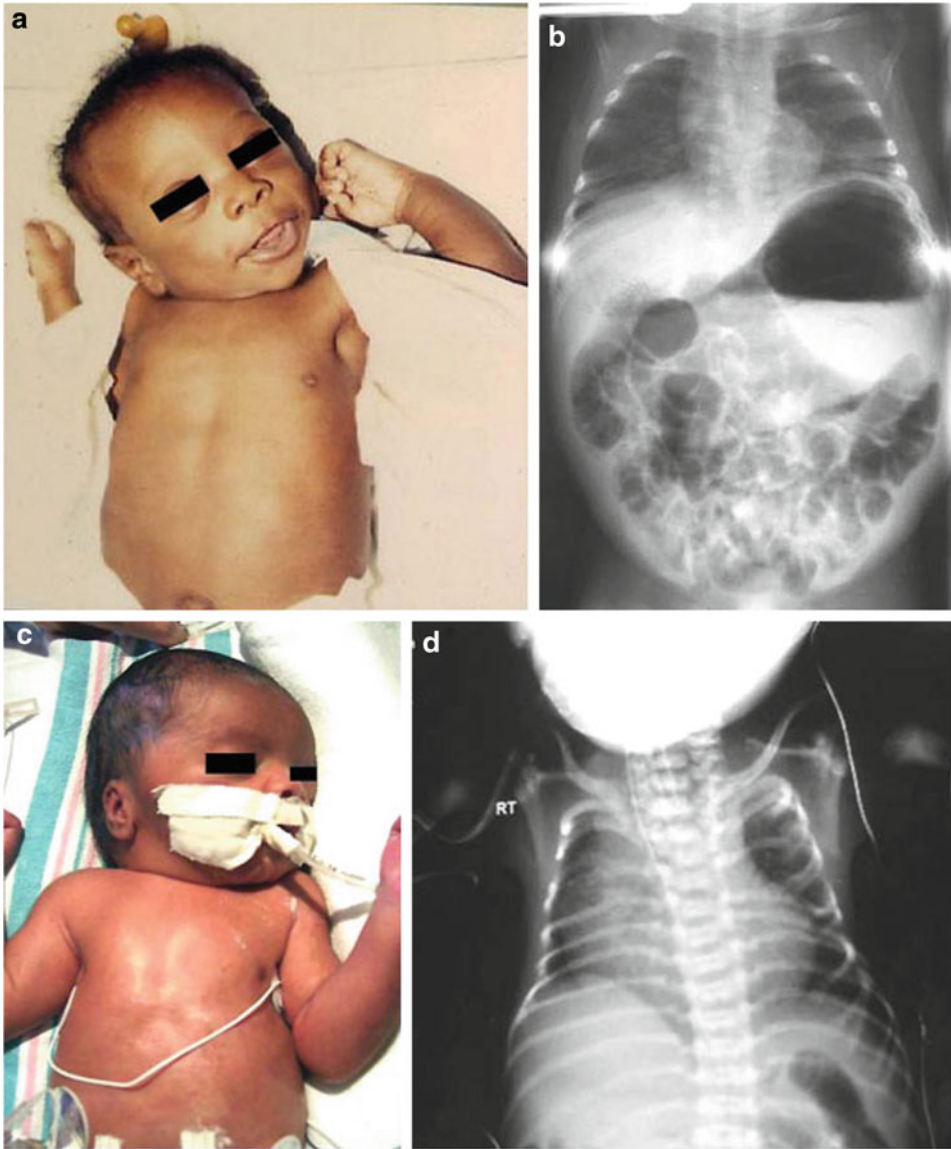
(a–d) Two infants (a, c) with spondylocostal dysostosis with typical crablike deformities of the chest with fused ribs (radiographs) (b, d)
